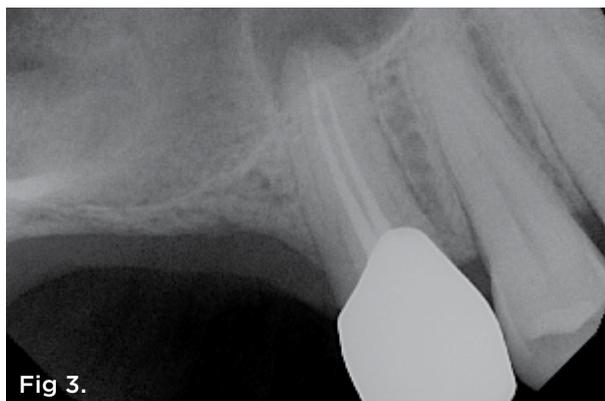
Final root canal fill with apical communication of the two canals during the same procedure. Note a small amount of apical resorption. Fig 4. The postoperative image. Note the apical dilaceration of the mesial canals. Fig 5. The digital x-ray clearly shows that all portals of exit are sealed. Fig 6. Digital imaging allowed the clinician to check the final fill before the endodontic temporary access was placed, and the rubber dam was removed.
